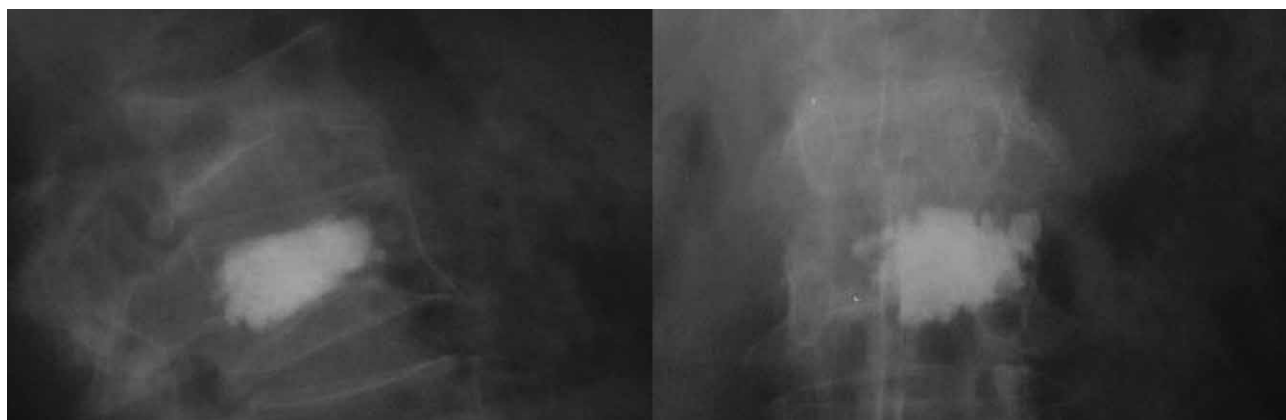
X-ray taken after the cement application.
